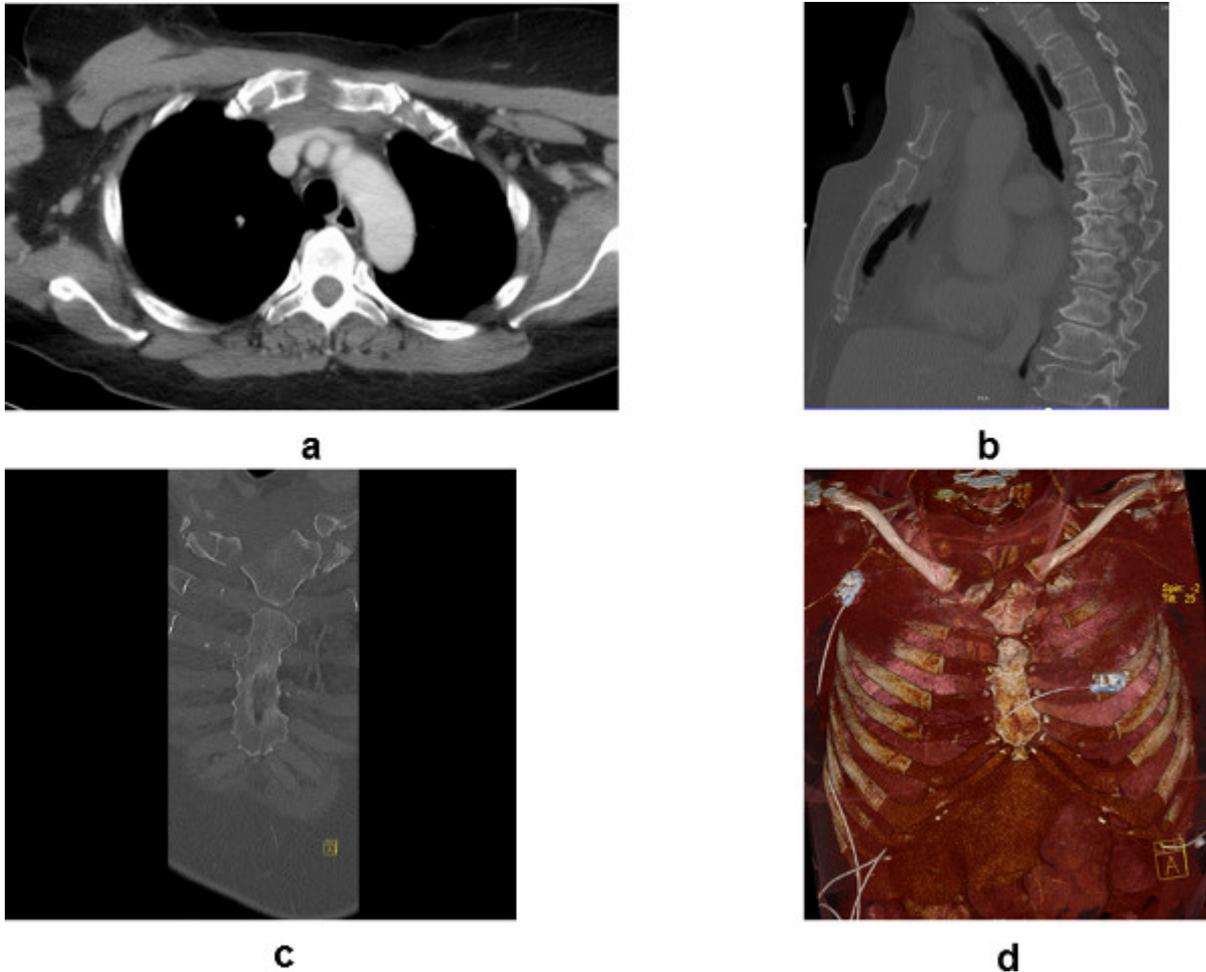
Preoperative CT-Scan. (a) Axial view shows oblique and longitudinal fractures. (b) Sagittal view shows anterior-posterior dislocation or sternal kinking. (c) Coronal view gives an overview over oblique and longitudinal fractures. (d) Volume rendering technique (VRT) gives an overview over the entire anterior chest wall showing rib fractures, manubrium and corpus sterni fracture
